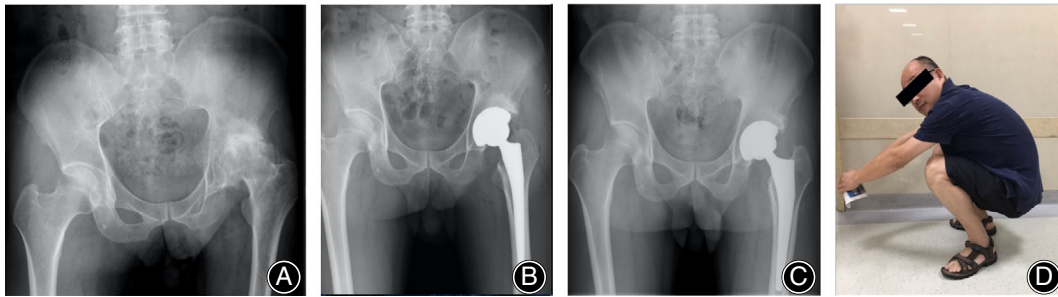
Radiographs of a 42-year-old man with osteoarthritis secondary to infection of the hip in childhood in the left hip. (A) Preoperative anteroposterior view. (B) Postoperative radiographic image at 1-week follow up. (C) Postoperative radiographic image at 8-year follow up with appropriate implant position and stable fixation. (D) The postoperative hip function at 8-year follow-up examination.
